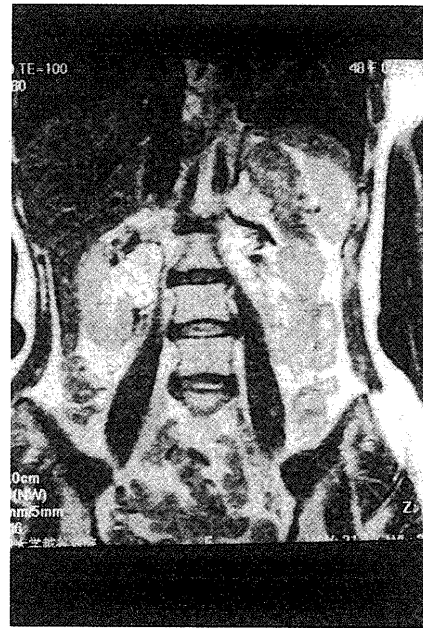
Magnetic resonance imaging shows a retroperitoneal mass invading to renal pelvis.
